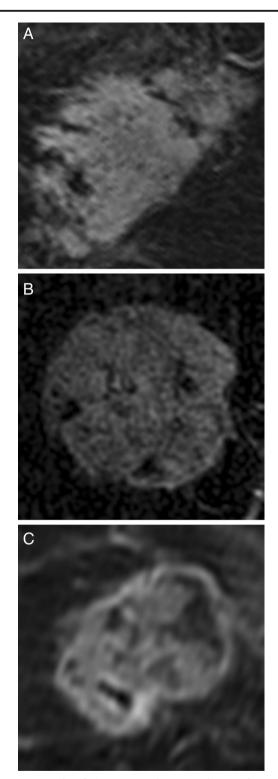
a-c Examples of Tl postcontrast breast MRI images of tumors that underwent CNN evaluation in our study from patients with complete pathologic response
